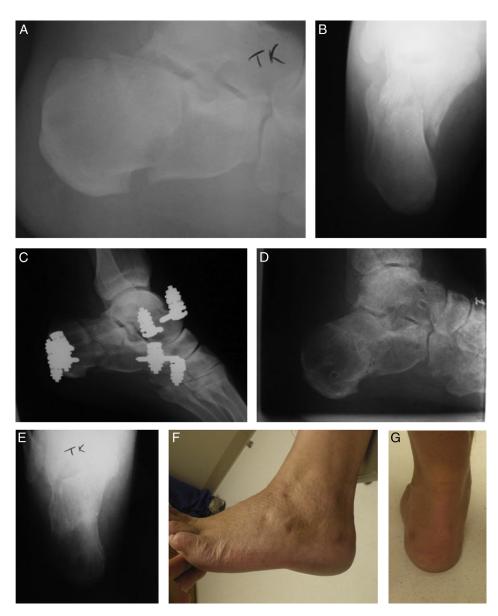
Case 2. (*A* and *B*) Calcaneal fracture radiographs showing joint depression, shortening, and severe varus position of the posterior calcaneus. (*C*) The length has been restored, varus position reduced, and stabilization provided with bilateral external fixation. (*D*) The fracture has been reduced, and radiographic evidence of healing at 8 weeks after reduction just after frame removal. (*E*) Calcaneal axial radiograph showing reduction and healing of the calcaneus in anatomic position. (*F* and *G*) Clinical evidence of excellent soft tissue healing, a normal clinical position, and minimal scarring at 4 months after reduction.
